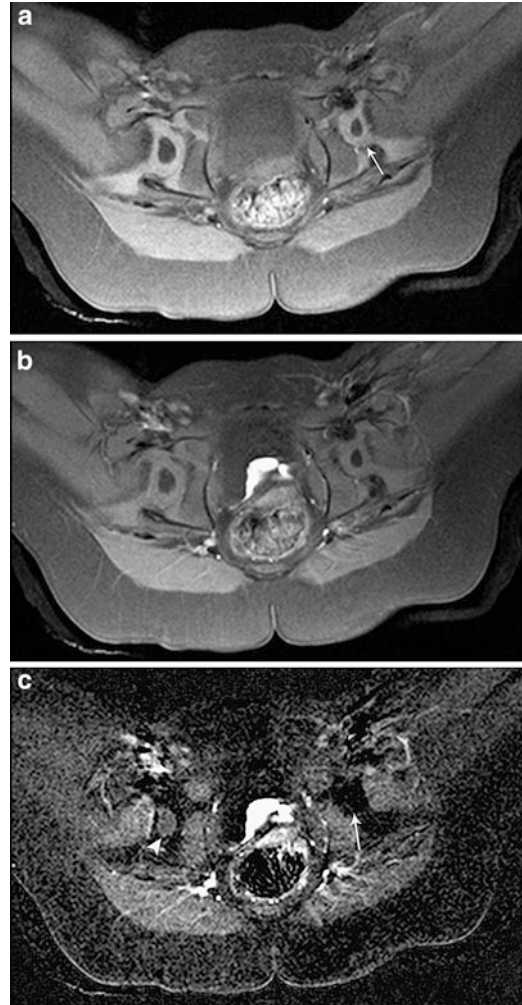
Thirteen-month-old girl with developmental dysplasia of the left hip status post closed reduction and SPICA cast placement with immediate post-reduction MR imaging. (a) Axial T1 fat-saturated image shows a small left femoral head within a shallow acetabulum (*arrow*). The right hip is normal. (b) Axial T1 fat-saturated post-gadolinium image shows asymmetric appearance of the ossification centers with decreased SI on the left. (c) Axial subtraction images demonstrate non-enhancement of the left femoral head ossification center (*arrow*). No epiphyseal vessels are seen within the cartilage of the left femoral epiphysis. Normal enhancement of the right femoral head ossification center is present (*arrowhead*). The patient was subsequently recasted
